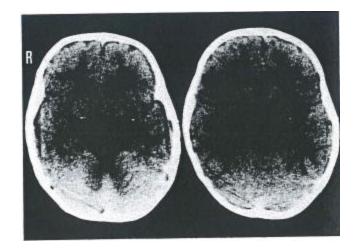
In the CT scans, it's observed that there are small areas of low density in the left thalamus (indicated by arrowhead) and in both sides of the putamen (marked by arrows). Additionally, the widened spaces in the subarachnoid area of the brain have disappeared.
